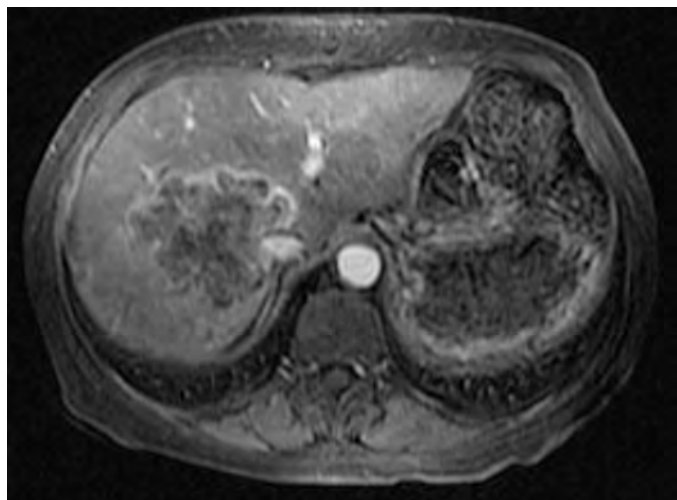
Pyogenic liver abscess: MRI findings. Gadolinium-enhanced, fat-suppressed T1-weighted image shows a predominantly low signal intensity mass with enhancing wall and septations.
